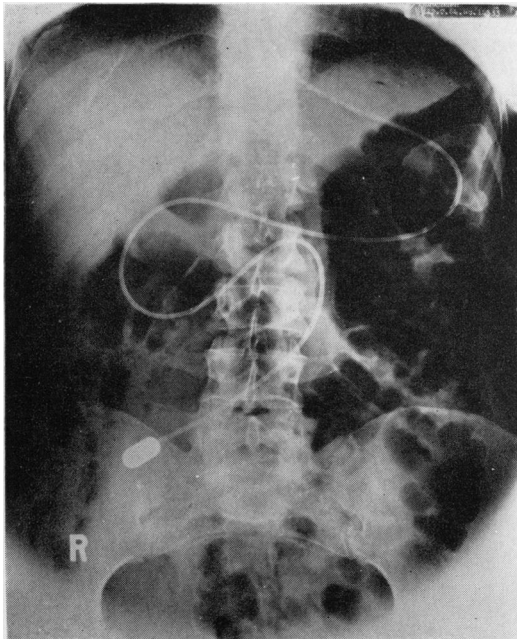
Radiograph showing Crosby capsule in small intestine.
